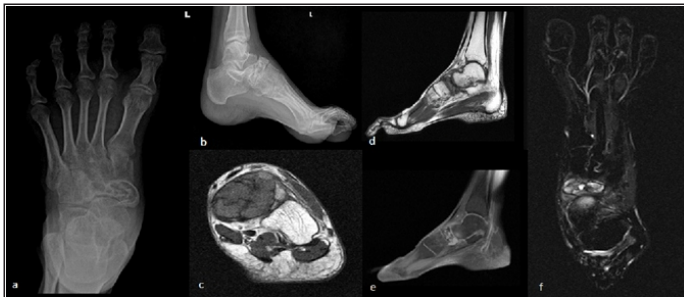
Plain radiographs of foot and ankle showed navicular expansile lytic lesion (a and b), Computed tomography scan showing well-defined lytic lesion with sclerotic margin and narrow zone of transition with cortical breach (c and d), Magnetic resonance imaging shows altered signal intensity lesion (which is heterogeneously hypointense on T1WI and hyperintense on T2WI showing fluid levels (e and f).
